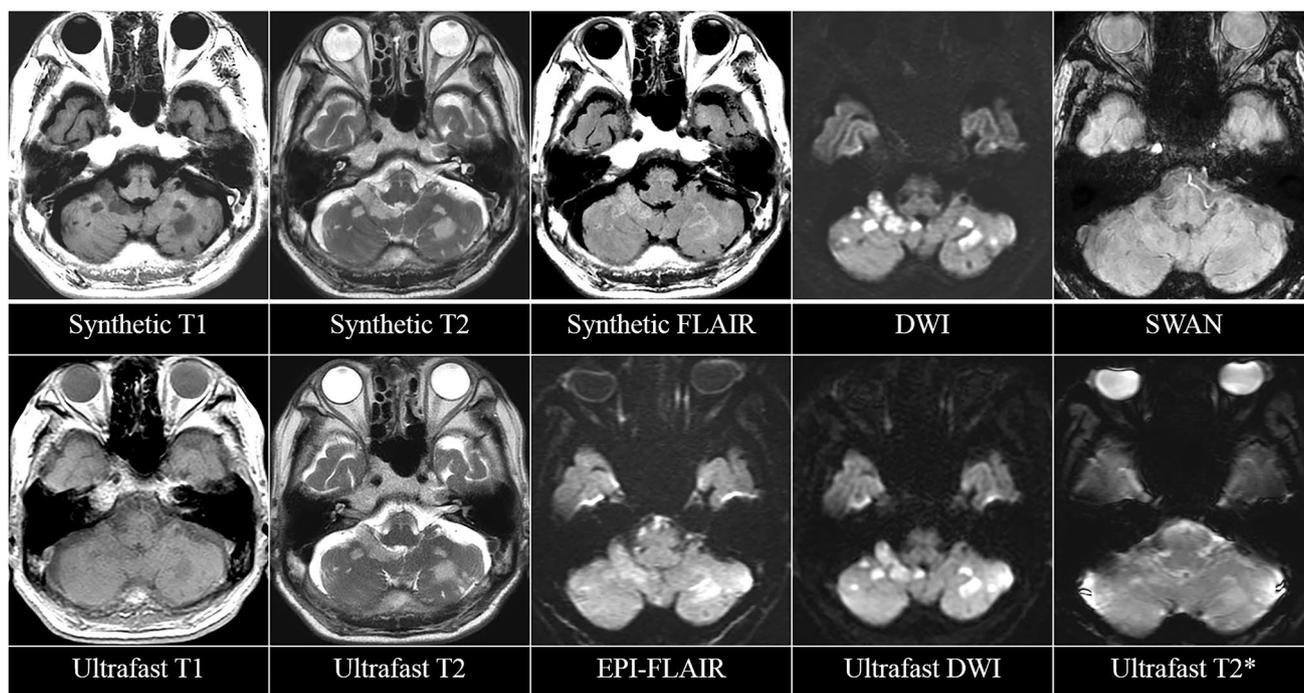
Acute infarction in the bilateral cerebellar hemispheres in an 82-year-old man. Multifocal diffusion restrictions are apparent in the bilateral cerebellar hemispheres with T1 hypointensity, T2, and FLAIR hyperintensity. These lesions appear similar on routine (upper
